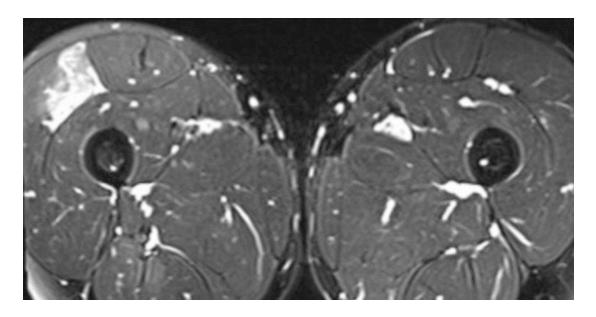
Axial fat-suppressed T2-weighted MRI of right mid-thigh discloses moderate muscle contusion of the vastus lateralis without aponeurosis rupture
